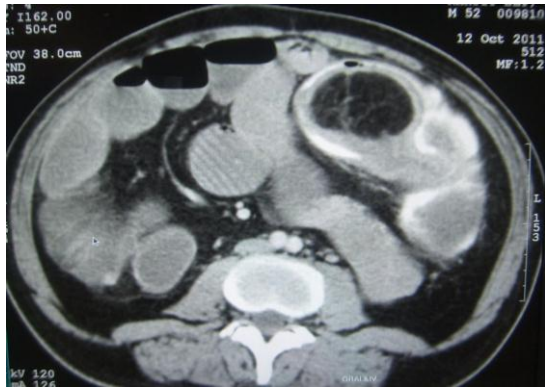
CT shows colocolic intussusception.
